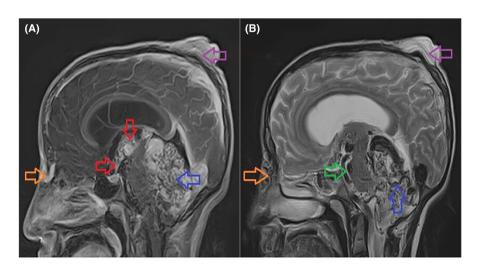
MRI brain and orbits. (A) Coronal T1-weighted image with contrast enhancement and (B) Coronal T2-weighted image with contrast enhancement demonstrate AVM involving the cerebellar hemispheres (blue box) and the left superior parietal region causing a soft tissue swelling (green arrow) and hyperostosis of the underlying parietal skull bone (red arrow). Dilation of the lateral ventricles (purple arrows) and dilation of a draining vein (orange arrow) is also seen.
